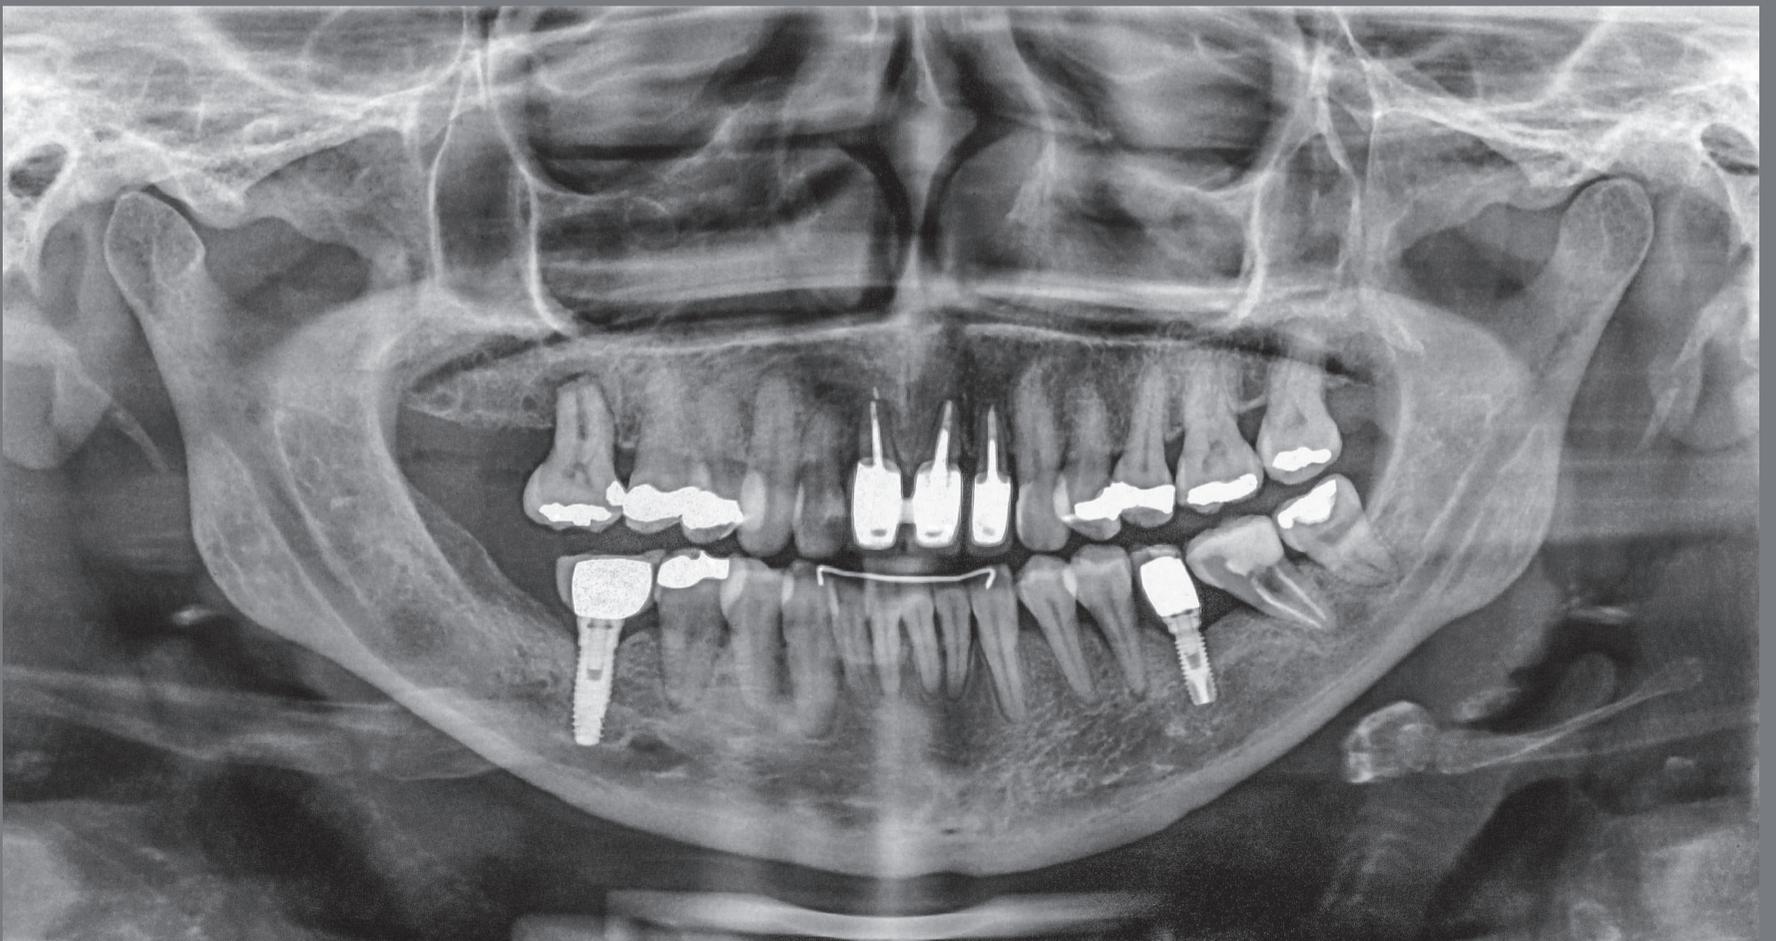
Panoramic radiograph 8 years after the end of treatment.
